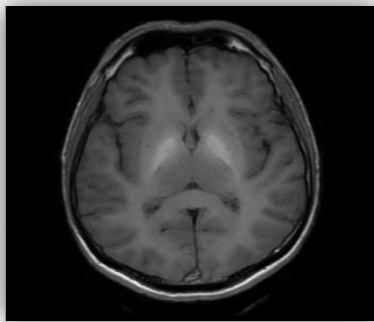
MRI image of the worker exposed to Mn with T1W hyperintensity.
